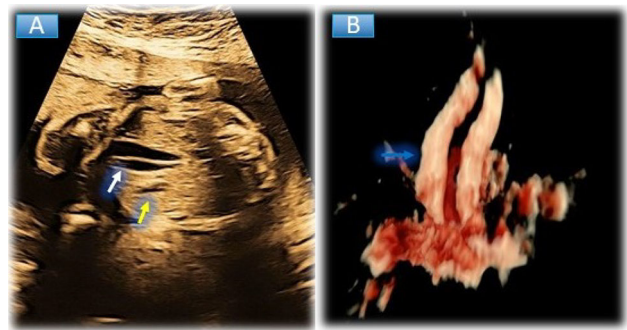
Antenatal Ultrasound, A 2D Greyscale image at the level of the fetal upper abdomen and B HDlive rendered image, demonstrating two pear-shaped parallel anechoic structures in the gall bladder fossa (white arrow), right lateral to the umbilical vein (yellow arrow), HDlive rendered image showing the same with no clear delineation of the cystic duct
